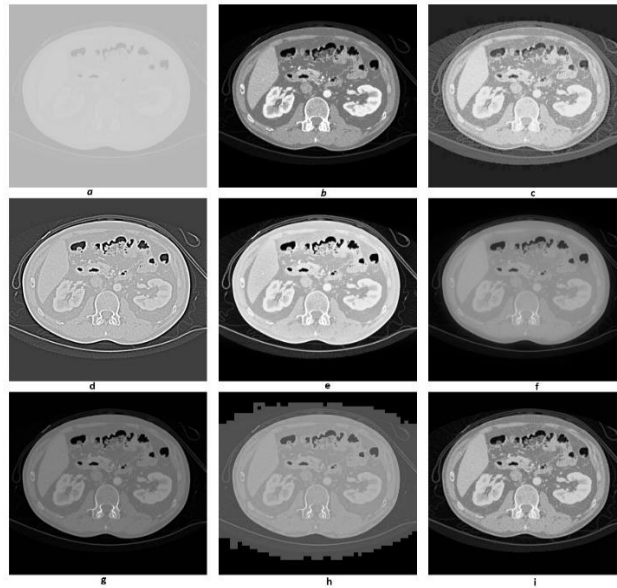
Enhanced test CT image of Abdominal by a) Reinhard (b) Kim (c) Khan (d) Li (e) Liang (f) Shibata (g) Al-Ameen (h) Gandhamal (i) Proposed, in the reading order.
